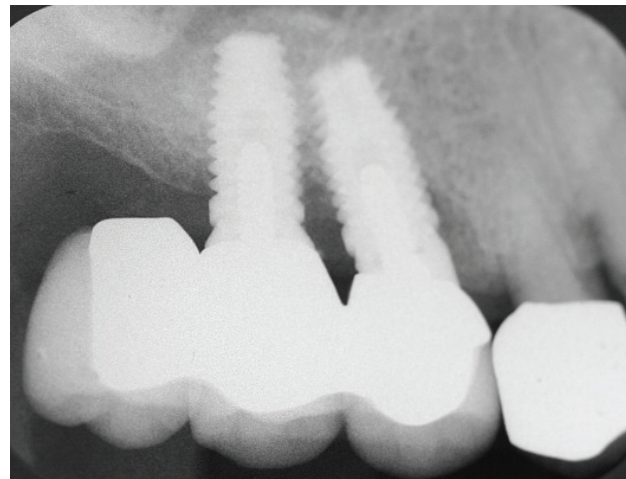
Periapical radiograph of a cantilevered bridge (teeth nos. 3-5) with two 4.1-millimeter-diameter implants (teeth nos. 4 and 5) supporting the prosthesis. The pontic is over the sinus, where there was too little bone to place an implant. This radiograph was obtained at a three-year follow-up appointment. Components and prosthesis design are similar to those shown in Figure 1.
